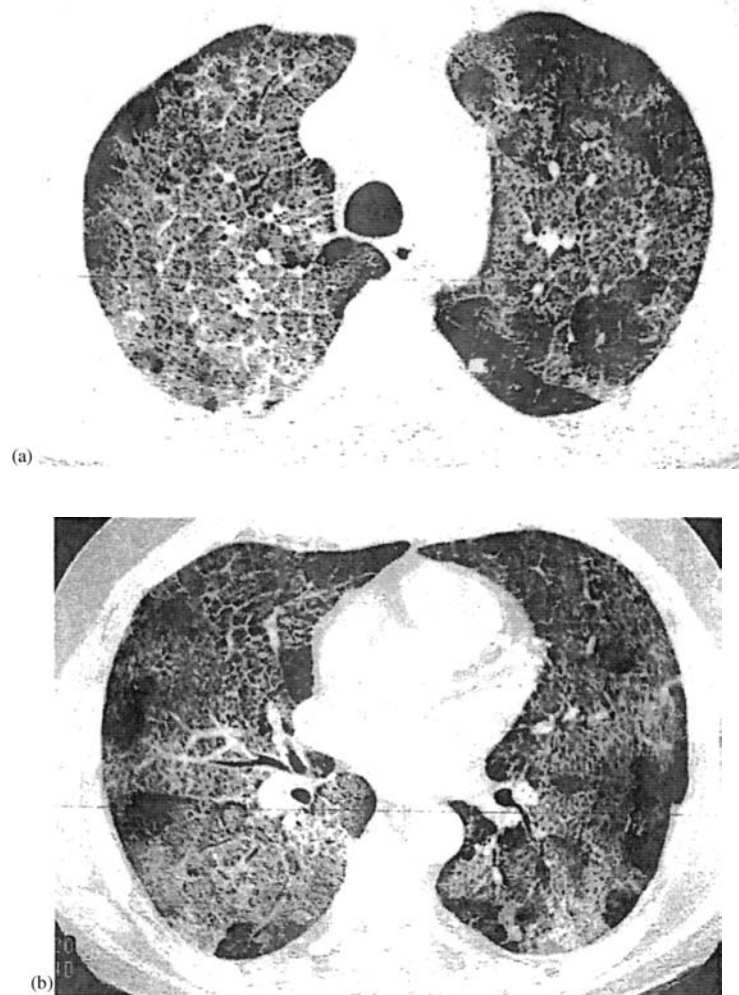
(a) Pulmonary alveolar proteinosis. HRCT (upper lobes) demonstrates the crazy-paving pattern, with a network of thickened interlobular septae superimposed on ground-glass attenuation. (b) Pulmonary Alveolar Proteinosis. HRCT from the same patient (lower lobes) demonstrates extensive GGO and a “crazy-paving” pattern.
